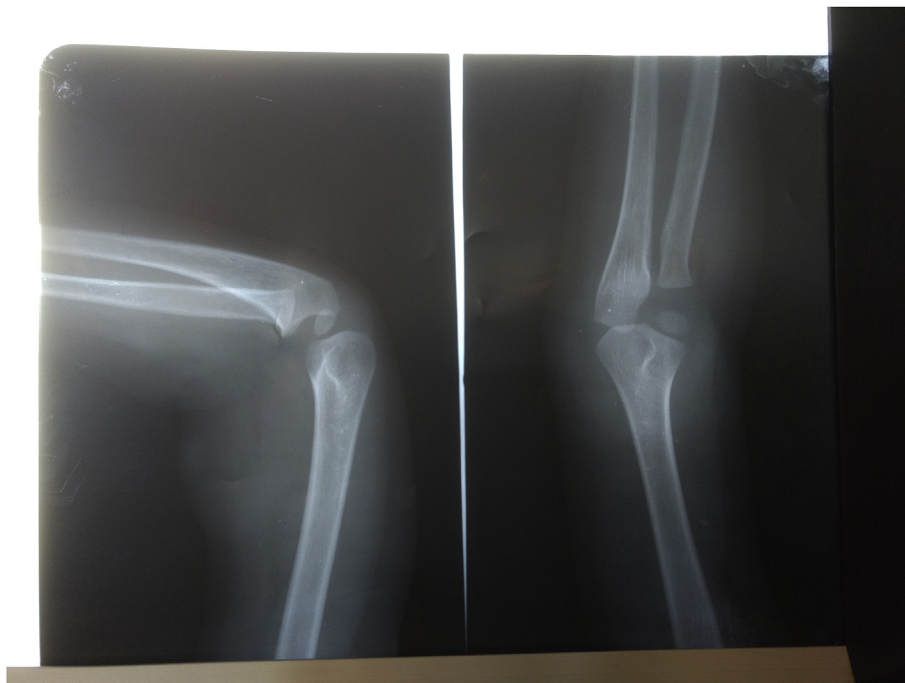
X-ray of right arm.
